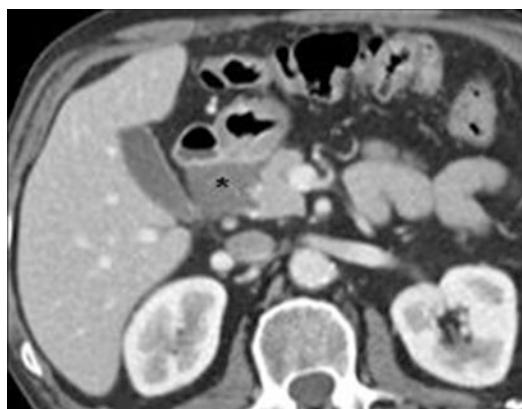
Groove pancreatitis in a 47-year-old man with right upper quadrant pain and normal serum amylase. Axial abdominal CT image with intravenous contrast shows low attenuation mass-like soft tissue in the pancreaticoduodenal groove (asterisk), which is consistent with groove pancreatitis, and which was confirmed with endoscopic ultrasound and biopsy
